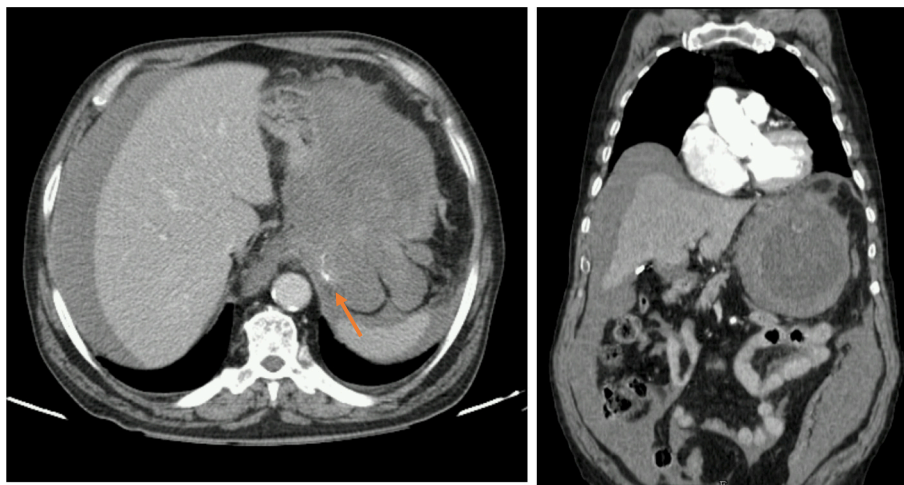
Computed tomography image on admission: voluminous exophytic lesion on the posterior surface of the stomach body with active bleeding (arrow) and hemoperitoneum.
